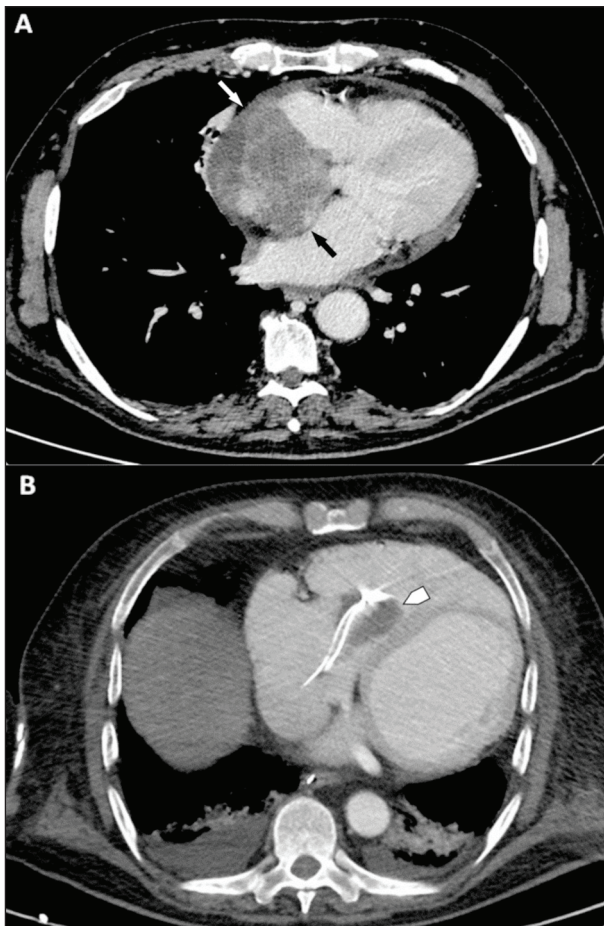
Voluminous sarcoma arising from the right atrium (A) vs thrombus in the right ventricle (B). In A the mass shows invasion of inter-atrial septum (black arrow), inferior vena cava, and pericardium (white arrow) (which appears thickened with a thin pericardial effusion); on CT venous phase, the mass shows heterogenous enhancement. In B in the right ventricle a catheter tip-related thrombosis (white arrowhead) shows hypodensity without CE on CT venous phase (B).
